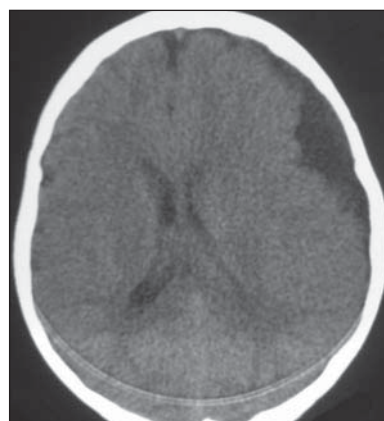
CT scan eight months after the beginning of symptoms showing complete resolution of subdural hematoma and arachnoid cyst without changes.
